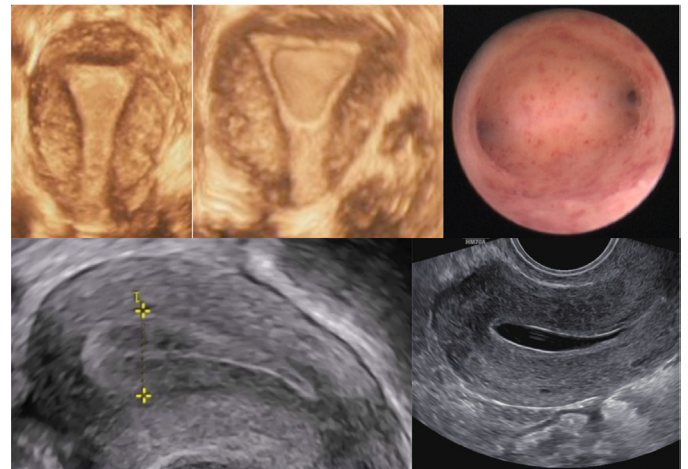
Normal ultrasound and hysteroscopy criteria.
